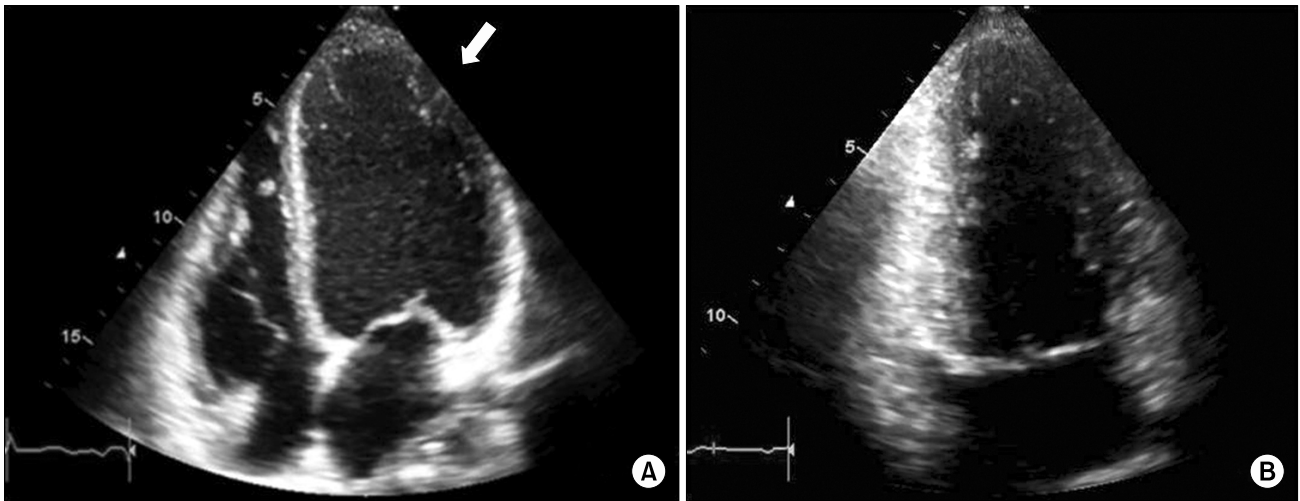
(A) Postoperative echocardiography shows apical ballooning (arrow). (B) Normalized echocardiography at discharge.
